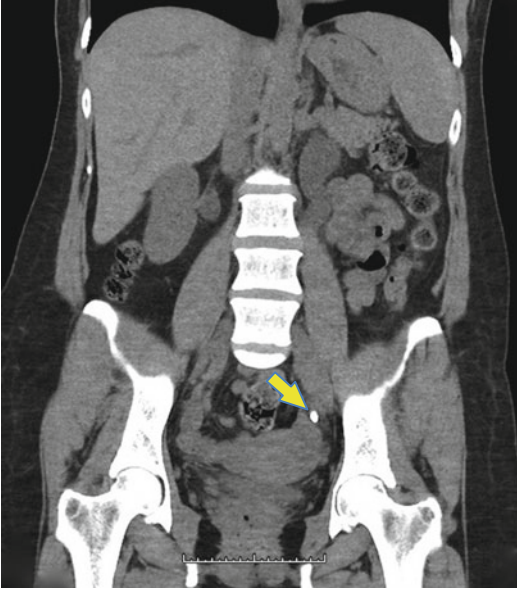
Coronal CT scan image of a left ureteral stone (yellow arrow)
